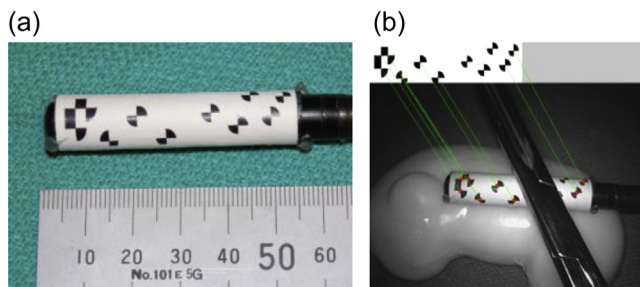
(a) Three-dimensional pattern attached to the back surface of the tubular ultrasound transducer. The visual tracking algorithm works in the presence of occlusion and endoscopic lighting variations (b).
